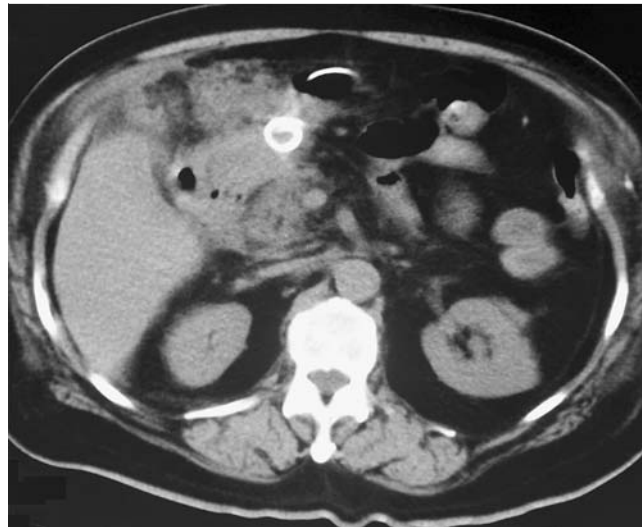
Post EUS-guided drainage contrast-enhanced computed tomography (CECT) view showing pigtail of the nasocystic drain in the abscess cavity.
